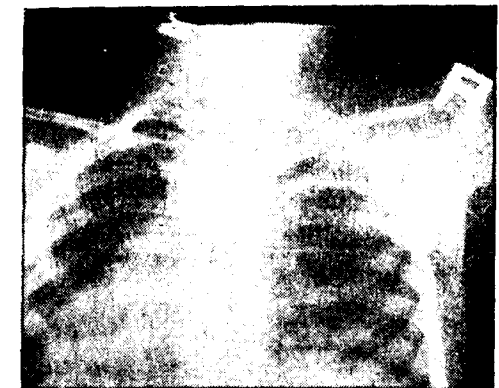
X-ray showing the greenstick fracture of clavicle without displacement.
